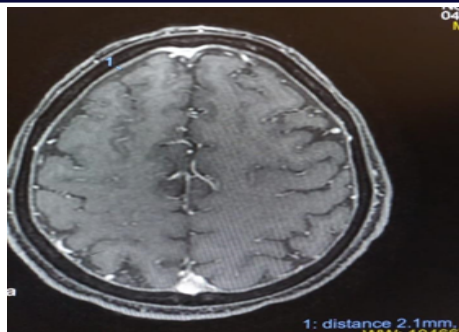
Figure legend: Figure 1: CEMRI (Contrast Enhanced Magnetic Resonance Imaging) Brain showing pachymeningeal enhancement suggestive of pachymeningitis
